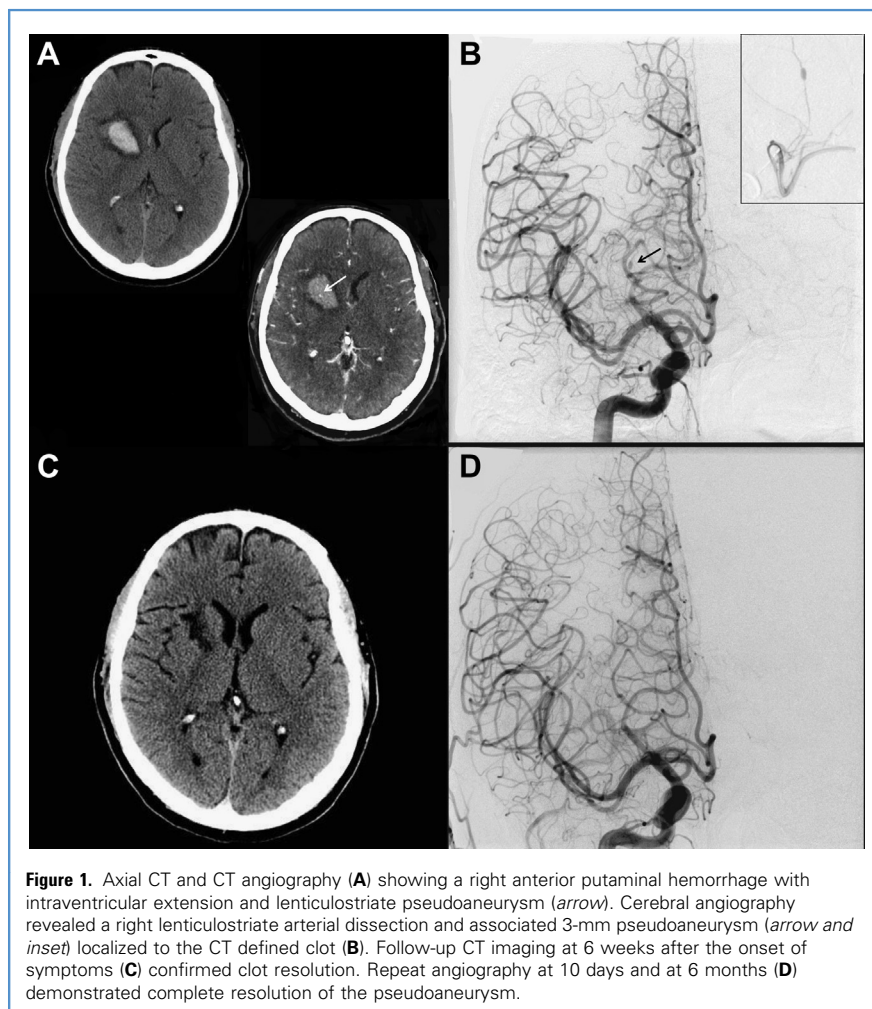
Axial CT and CT angiography (A) showing a right anterior putaminal hemorrhage with intraventricular extension and lenticulostriate pseudoaneurysm (arrow). Cerebral angiography revealed a right lenticulostriate arterial dissection and associated 3-mm pseudoaneurysm (arrow and inset) localized to the CT defined clot (B). Follow-up CT imaging at 6 weeks after the onset of symptoms (C) confirmed clot resolution. Repeat angiography at 10 days and at 6 months (D) demonstrated complete resolution of the pseudoaneurysm.
